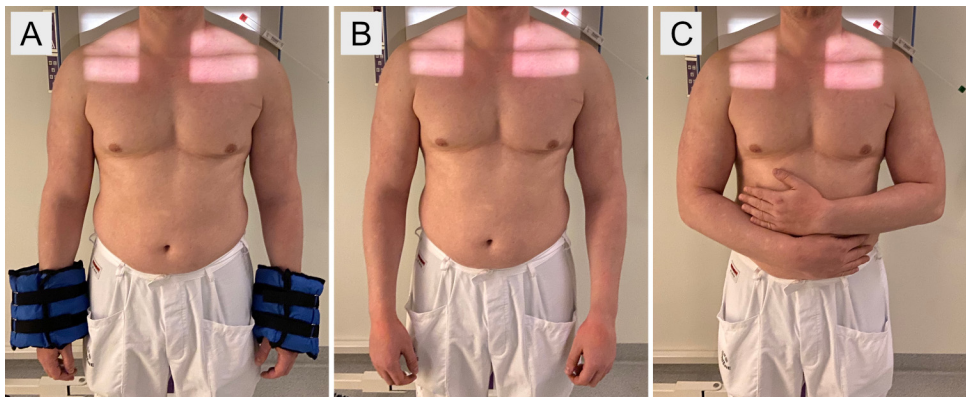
Patient positions for the study radiographs.
